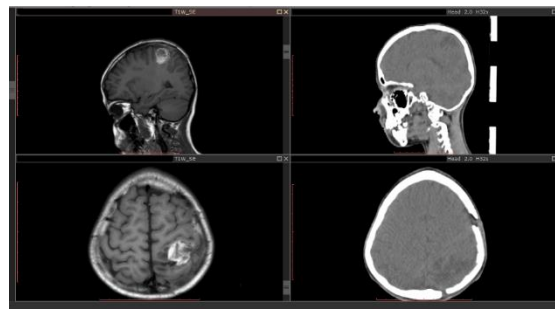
CT and MR images of patient with brain tumour
